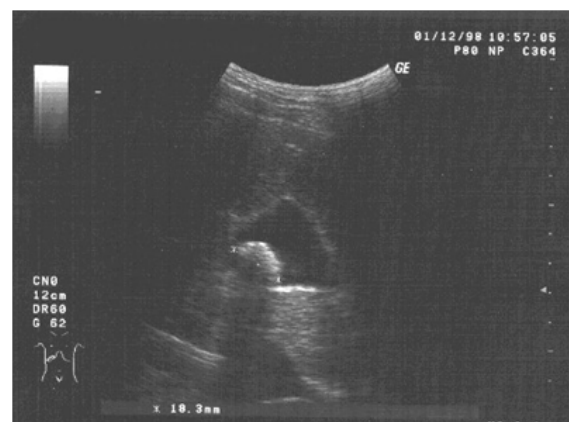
Initial (before the start of laser therapy) data of ultrasound examination of the gallbladder patient.
